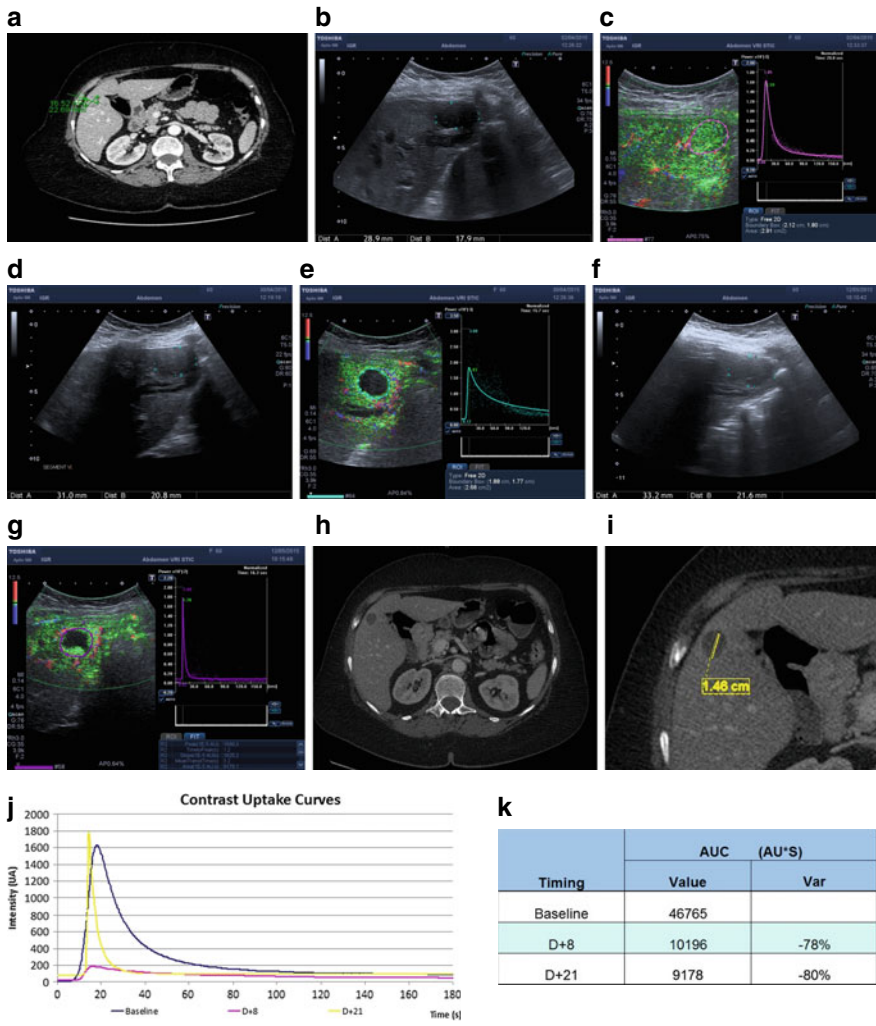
A woman 61 years old with metastasis from Uterine leiomyosarcoma was treated by antiangiogenic treatment. The targeted lesion was located in segment V of the liver. At baseline, a CT-scan a and DCE-US were performed. The lesion was hypoechoic on B mode (b) and hypervascularized on VRI (vascular recognition imaging) mode (c) after injection on 4.8 ml of contrast agent. DCE-US was performed at D8 after the start of therapy showing the same size on B mode (d) but a strong decrease in vascularization at the arterial peak (e). The results were confirmed at D 21 with DCE-US on B mode (f) et VRI mode (g). The CT-scan was performed after 2 months demonstrating a decreasing size of the hypodense nodule (1.46 mm) h, i. The graph (j) and the table (k) confirm that the biomarker AUC on DCE-US decreases more than 40% at day 8 and day 21
